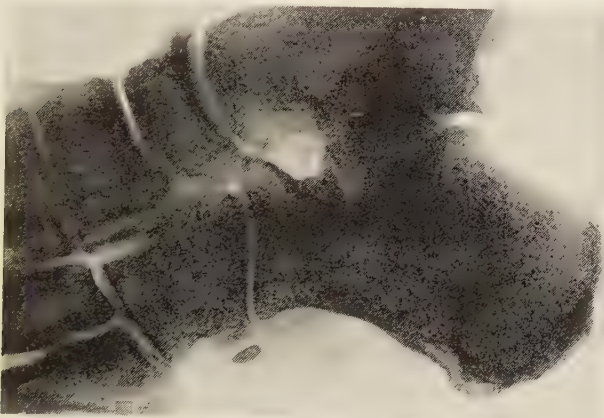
Female, aged 48. Only left foot radiographed. (BBH).
